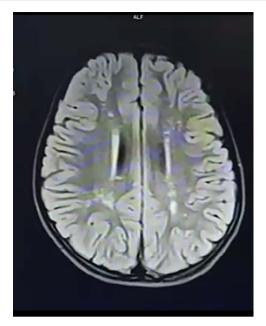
MRI imaging of the child showing metachromatic leukodystrophy.
